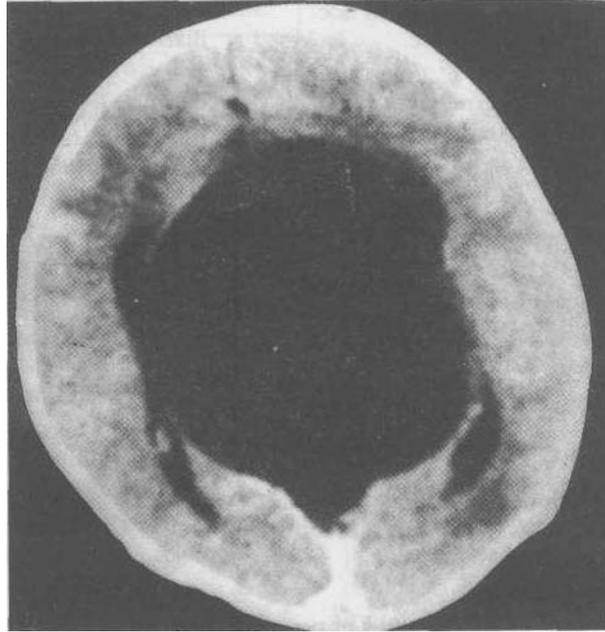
Computed tomography of the brain (coronal section) showing the interhemispheric cyst with agenesis of corpus callosum.
